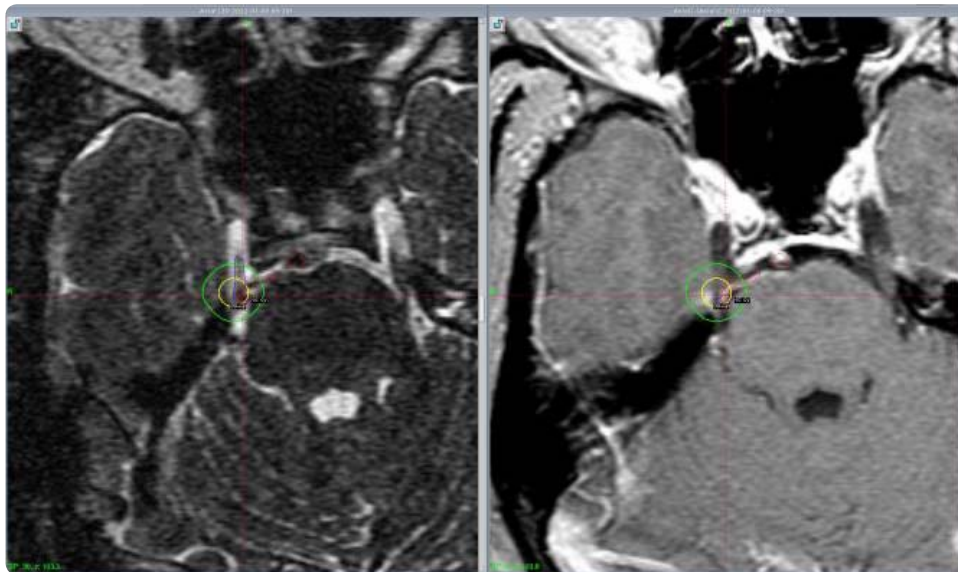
Axial 3D-T2 pre-contrast MRI and post contrast Axial T1 MRI images of the same patient in Figure 1 at gamma dose plan workstation showing the right trigeminal nerve which is drawn as blue lined structure and the blood vessel in contact which is drawn as red lined structure in both images confirm simultaneously the existence of NVC complex which is used as the target for GKS in treatment.
